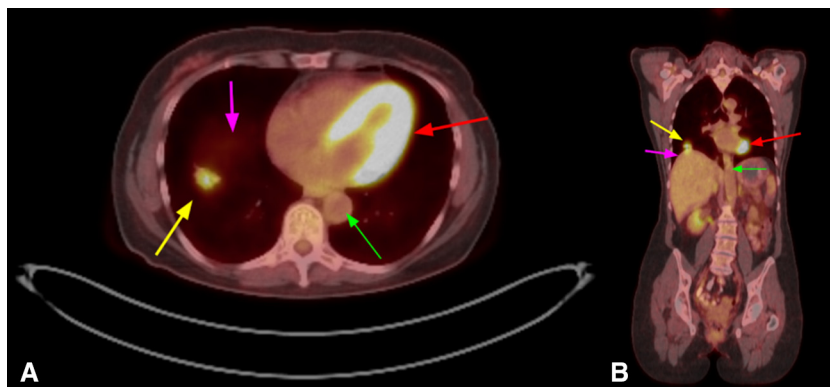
Positron emission tomography computed tomography (PET-CT) imaging of a patient with a primary lung lesion. A, Axial slice of PET-CT with *yellow arrow* indicating primary lung neoplastic lesion. *Purple arrow*: faint uptake at this level indicates superior border of liver. *Green arrow*: descending aorta. *Red arrow*: left ventricular wall. B, Coronal slice of same PET-CT shown in panel A, with *colored arrows* indicating same structures as in panel A: *Yellow*: primary lung neoplastic lesion. *Purple*: superior border of liver. *Green*: descending aorta. *Red*: apex of heart. Both images obtained with permission from Dr Errol Bush of Johns Hopkins Hospital.
